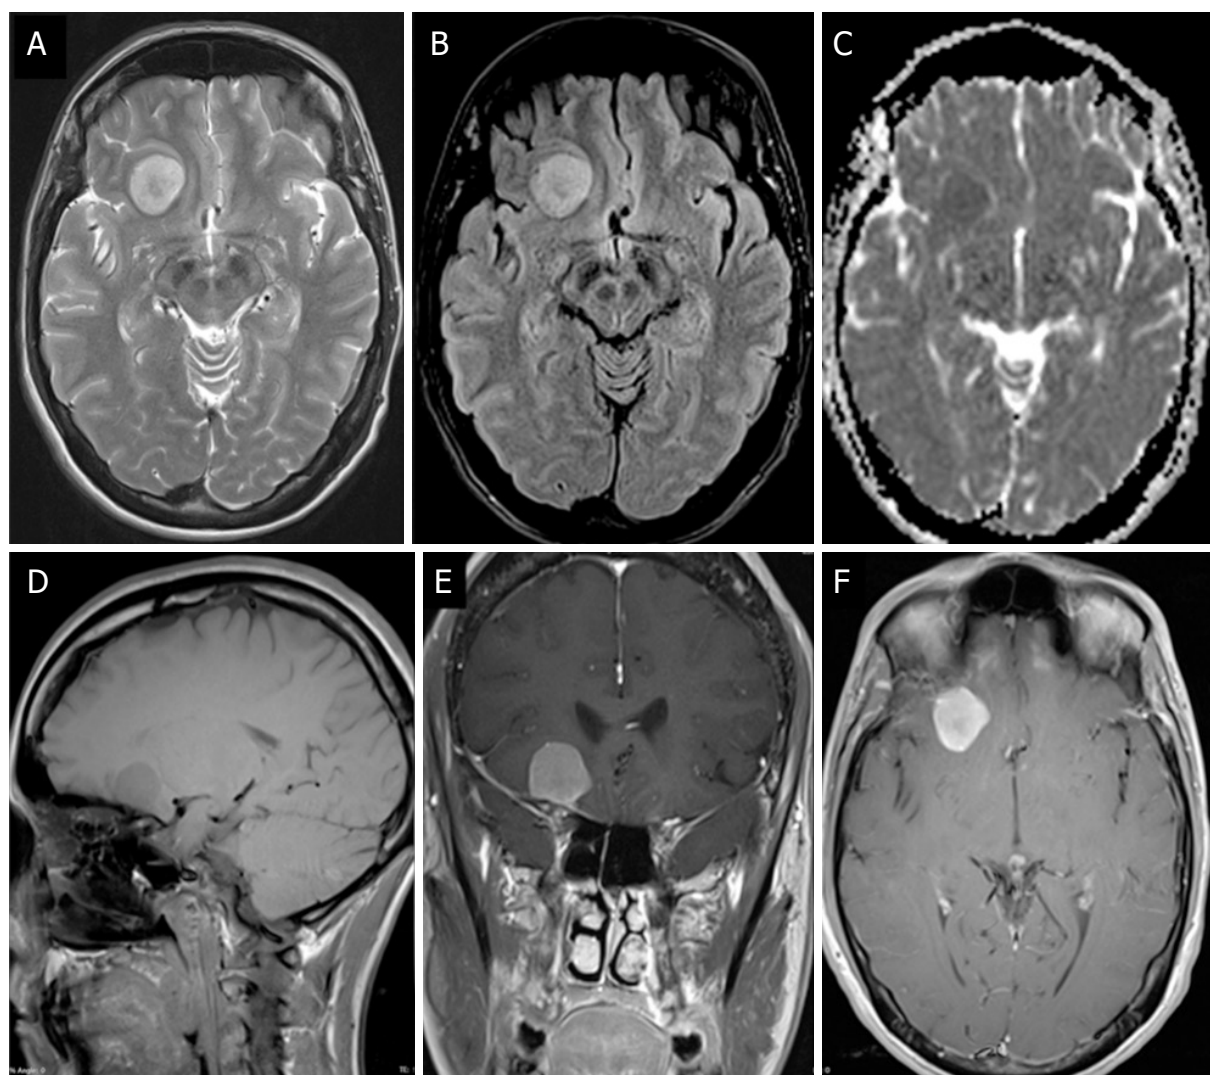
Right frontal low-grade meningioma on conventional MRI: hyperintense on T2w (A) and FLAIR (B) images, with no peripheral edema and a subtle crescent-shaped CSF cleft between tumor and adjacent brain tissue; no significant DWI restriction with moderate-to-high value on ADC map compared to brain parenchyma (C); and iso-hypointense relative to cerebral grey matter on T1w (D), with homogeneous and intense post-contrast enhancement (E, F). CSF: cerebral-spinal fluid; DWI: diffusion-weighted images; ADC: apparent diffusion coefficient
